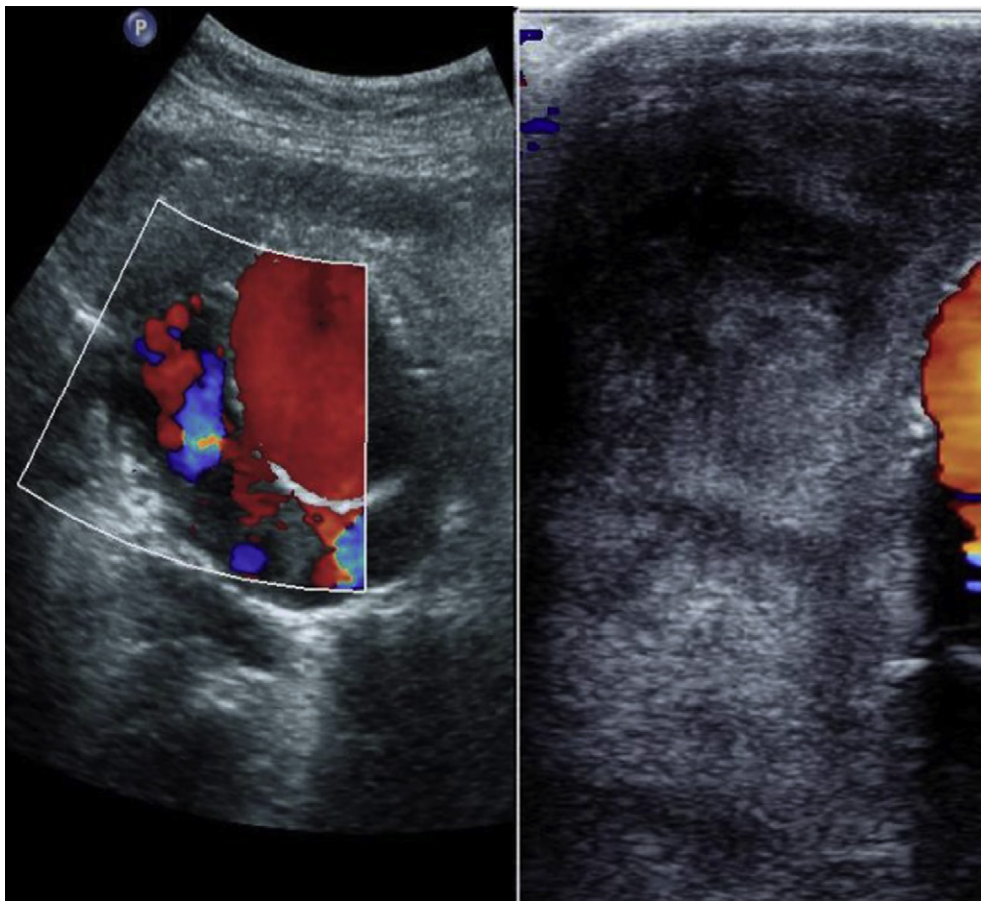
Left-Pre-operative ultrasound view demonstrating colour flow within the aneurysm sac. Right-Intraoperative duplex ultrasound: transverse view of superior aspect of aneurysm sac (linear 7–4 MHz transducer placed directly onto the anterior aortic surface) performed 10 min after aortic neck banding showing proximal cavities in the right lateral aspect of the aortic aneurysm sac that have sealed (centrally anechoic with no flow seen and hyperechoic rims, consistent with recent thrombosis).
